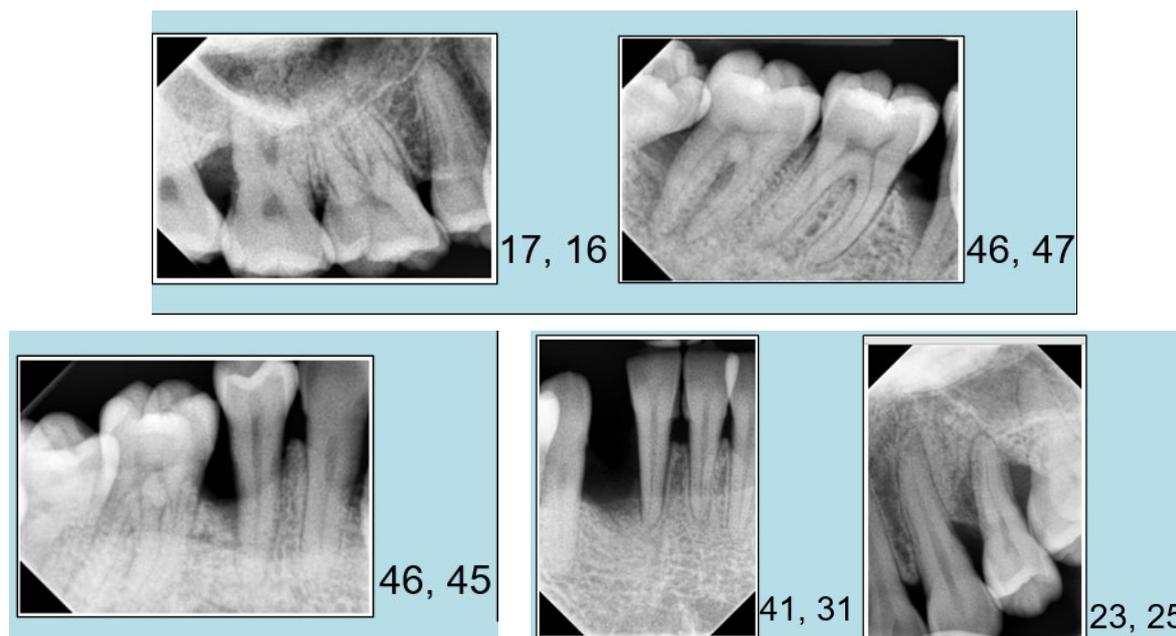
Intraoral periapical radiograph of Case 1.
